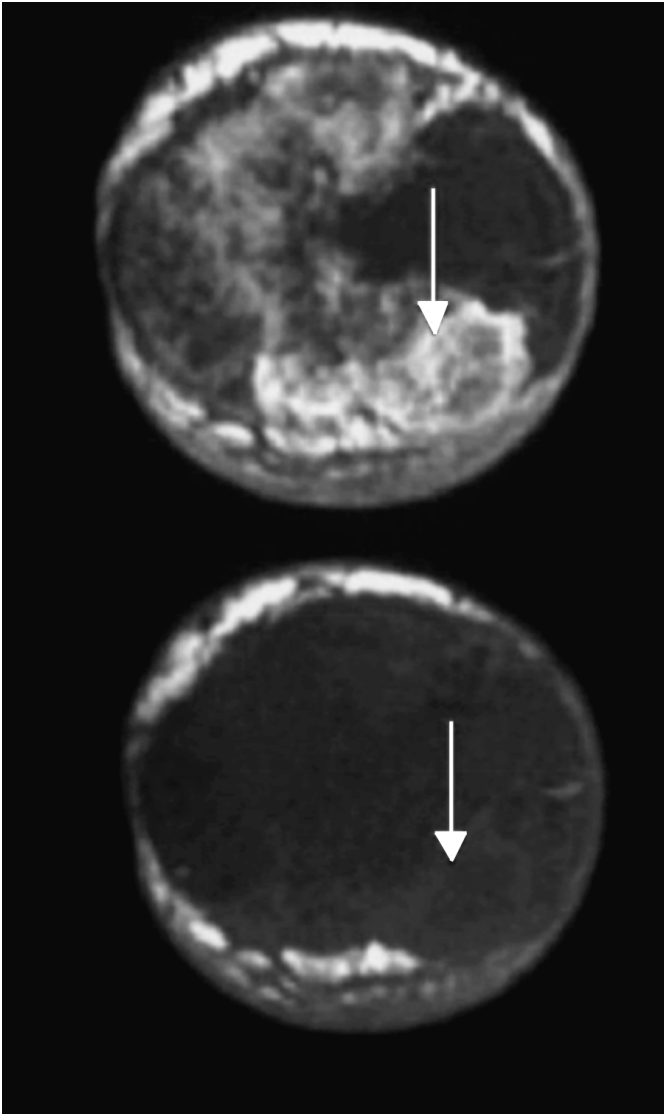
MRI (coronal images of left breast before (c) and after (d) administration of paramagnetic contrast): the mass shows inhomogeneous enhancement.
